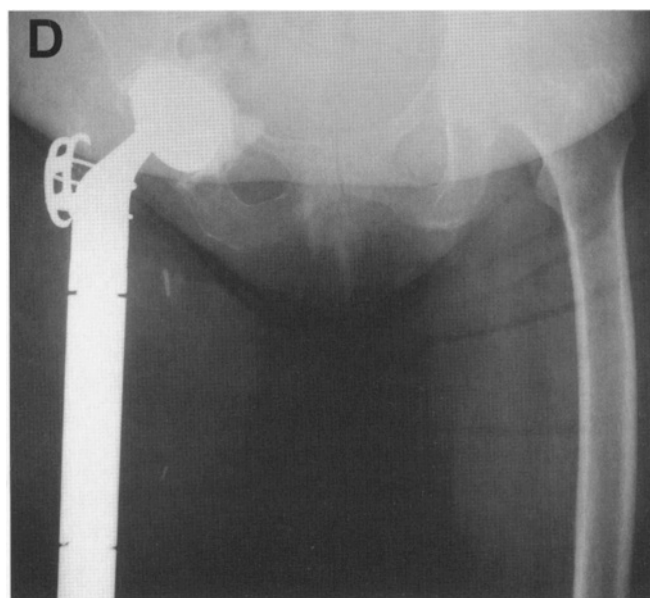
(A) Plain radiograph of a pending pathological fracture through a large benign fibrous dysplasia of the proximal femur. (B) Postoperative radiograph following curettage, cementation, and internal fixation. (C) Plain radiograph of the fixation of a multiple myeloma of the lesser trochanteric region of the proximal femur which has progressed despite radiation therapy and fractured with a plate and screws in place. (D) Postoperative radiograph following resection of the proximal femur.
